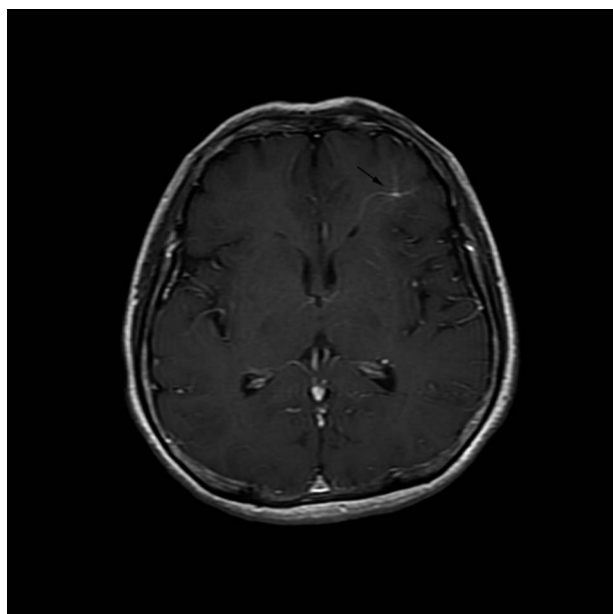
Magnetic resonance imaging with contrast of the brain showing a venous malformation in the left frontal lobe (arrow).
